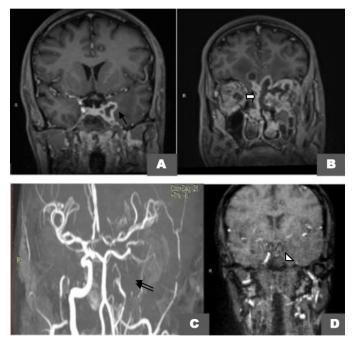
Post-contrast fat-saturated T1-weighted coronal (A, B) images showing an enhanced thickened wall of the left internal carotid artery and cavernous sinus (A) (arrow). Peripherally enhancement of the extending collection with focal basifrontal pachymeningeal enhancement (B) (plain arrow). MR angiography demonstrated a non-opacification of the left internal carotid artery involving both the intracranial and cervical portions (C) (double arrows), as well as the left cavernous sinus thrombosis (D) (arrow head).
